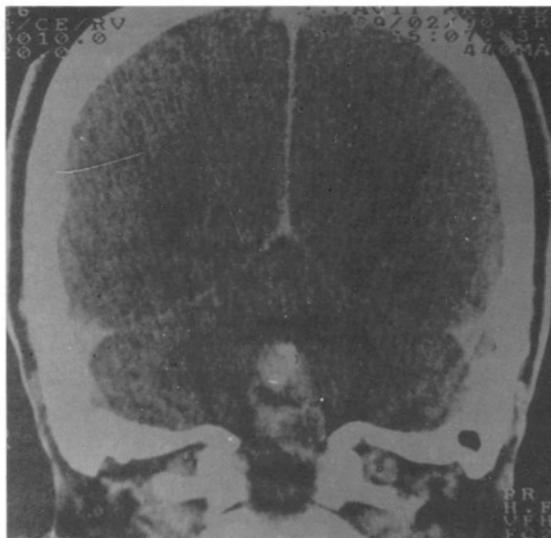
CT showing a large lesion in the mid-posterior fossa. There are three different areas of enhancement within the lesion. The upper part is hyperdense while the mid-portion has low density and the lower part is moderately enhancing.
